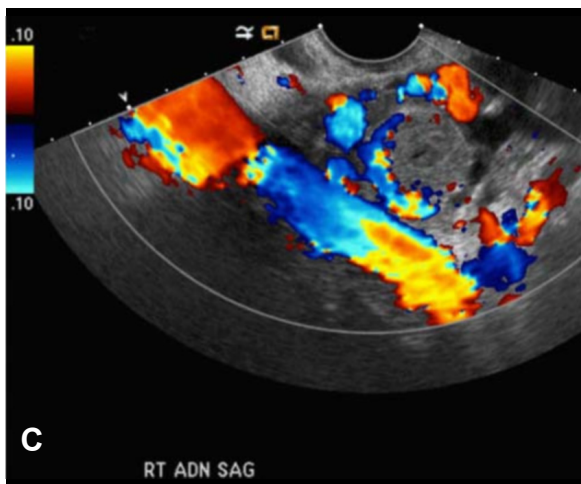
Color Doppler transvaginal imaging through the right ovary demonstrates a thick-walled cyst with peripheral flow consistent with a corpus luteum.
